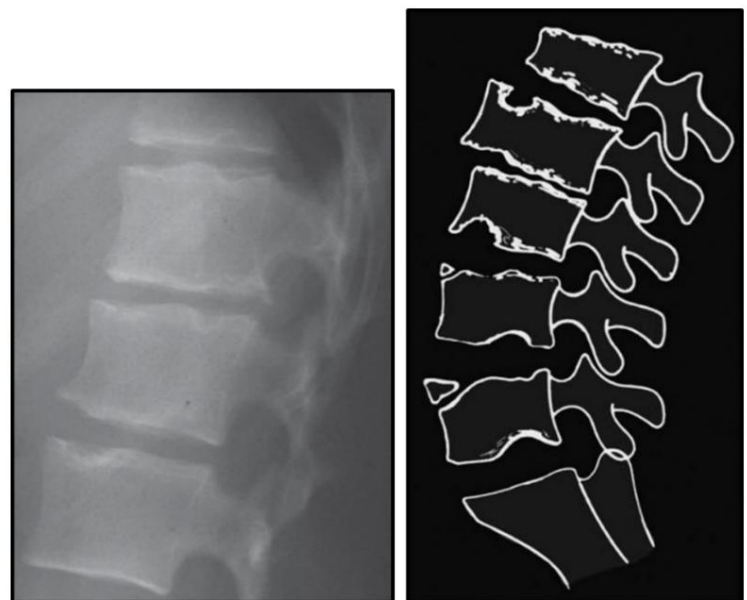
Lateral radiograph magnification with scheme of possible radiographic findings in Scheuermann's disease described in the text. Images taken from Palazzo's work, C. 2014.
